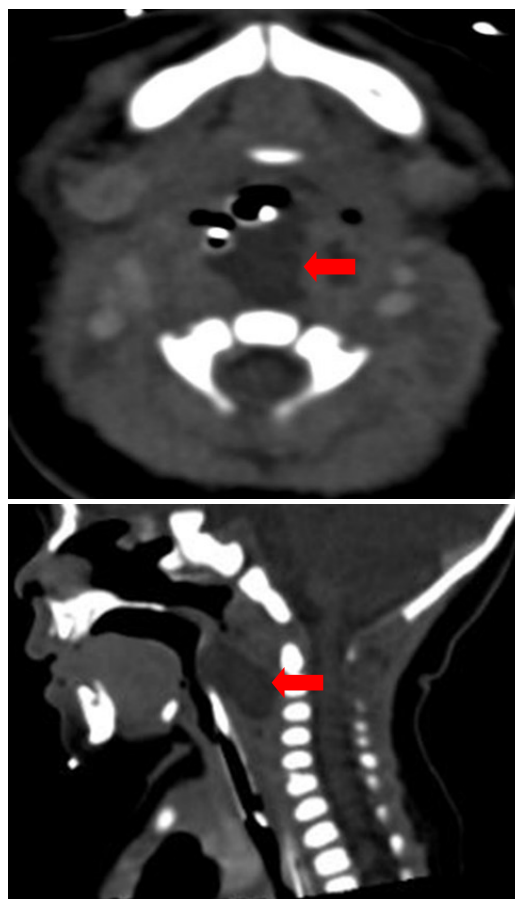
a) Axial contrast CT neck demonstrating ill-defined hypodense non-enhancing predominantly cystic lesion at left posterior pharyngeal wall extending to the prevertebral spaces with narrowing of the oropharynx (red arrow).
